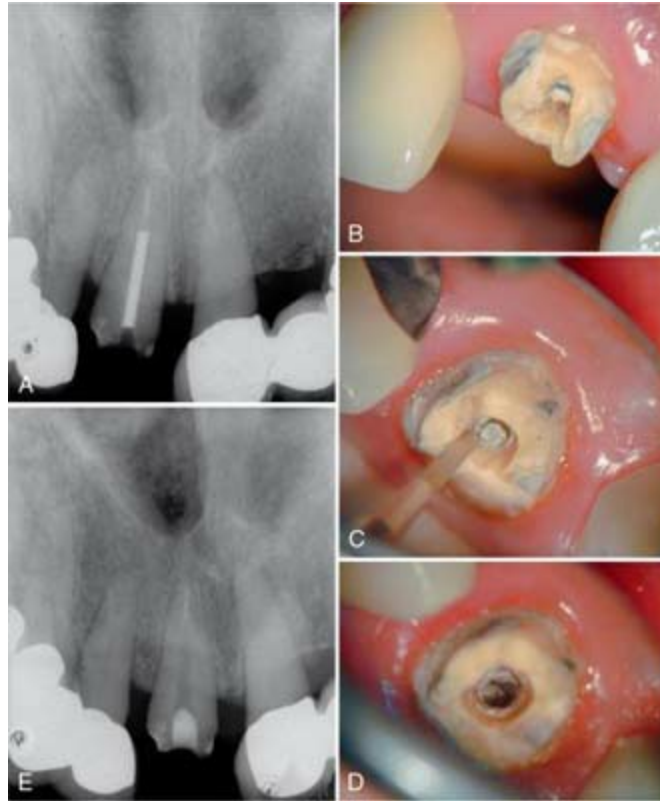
A, Radiograph of fractured post. B, Fractured post, labial view. C, Ultrasonic troughing. D, Post removed by ultrasonic alone. E, Check film confirming complete post removal.
